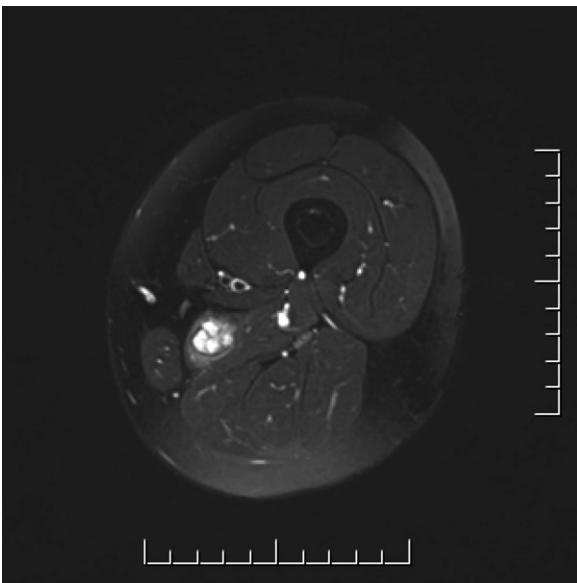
MRI of the left thigh showing T2 high-signal intensity lesion in the adductor magnus muscle.
